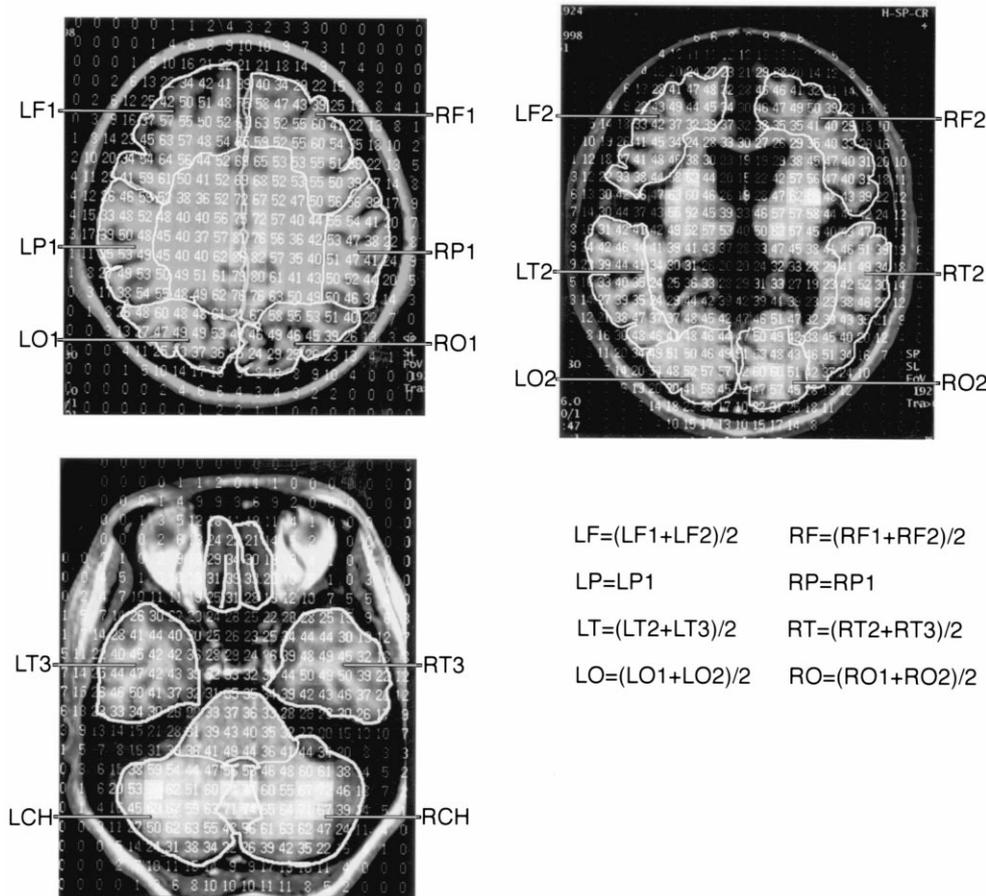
Example of the SPECT and MRI overlay imaging in one patient. The numbers shown upon the MRI are the rCBF pixel values (ml/100 g/min). The rCBF value in the regions in each segment was calculated as the mean value of each region. The final rCBF value in each cerebral lobe was calculated as shown in the lower right side of the figure. L = left; R = right; F = frontal lobe; P = parietal lobe; T = temporal lobe; O = occipital lobe; CH = cerebellar hemisphere.
